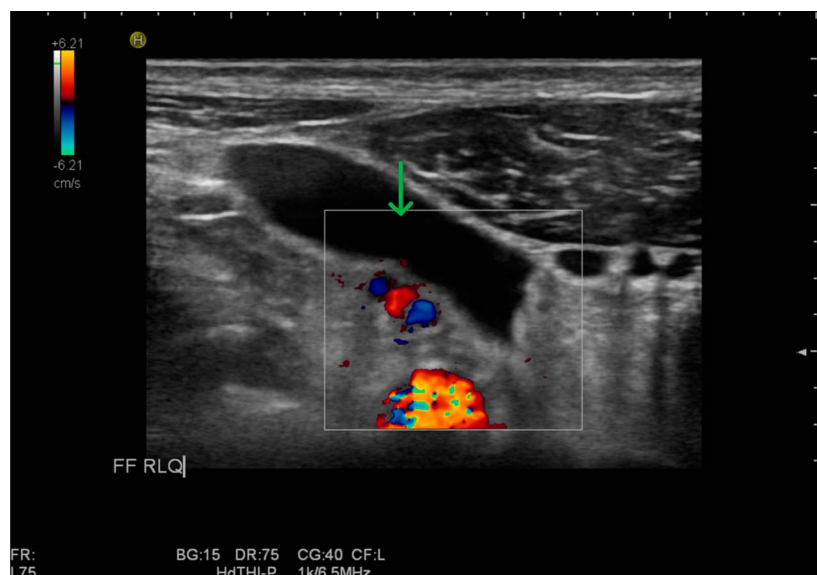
On follow-up intestinal ultrasound at 1 year, the right lower quadrant demonstrated free fluid (green arrow).
